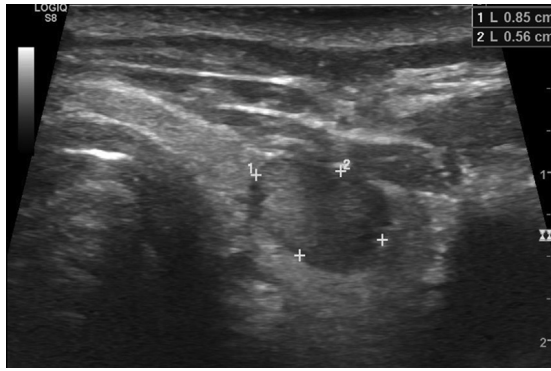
Intrathyroid parathyroid adenoma. Transverse sonogram of the left thyroid shows a solid, hypoechoic intrathyroidal nodule (*cursors*). FNA showed a PTH tissue washout level of 8832 pg/mL, consistent with an intrathyroidal parathyroid adenoma.
